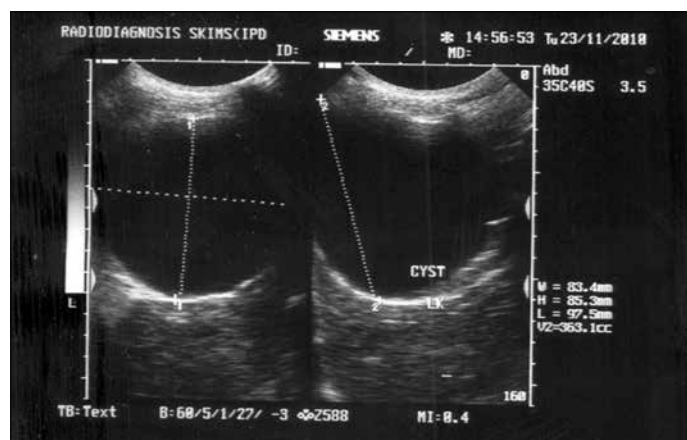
Ultrasound assessment of renal cyst parameters
